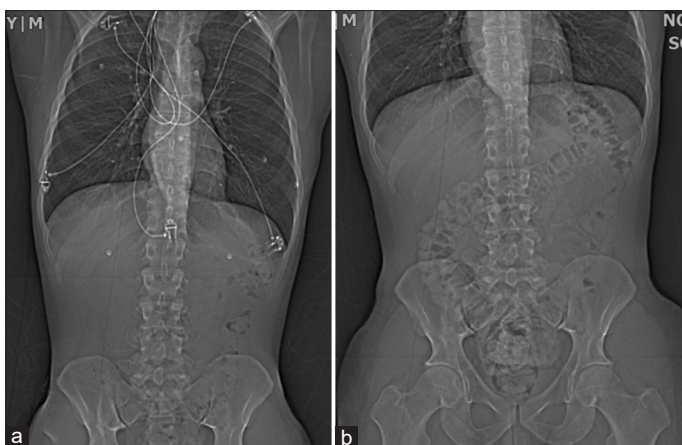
Computed tomography abdomen (a) without contrast and (b) with oral contrast
